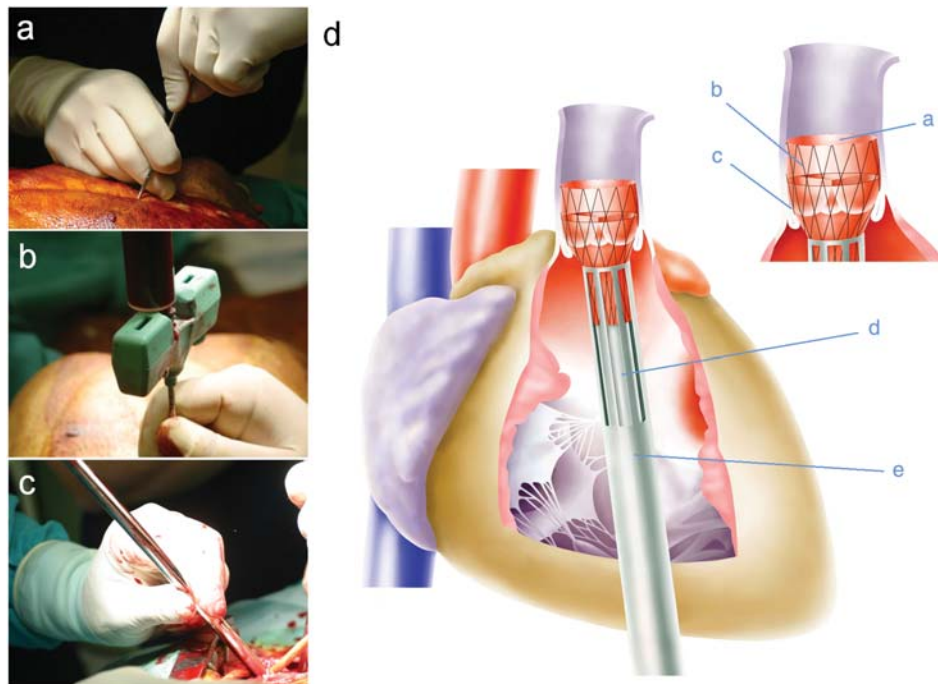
Minimally invasive tissue engineered heart valves implantation. After sternal bone marrow puncture (A) and aspiration of fluid (B), the tissue engineered heart valve was loaded into the delivery device (C), inserted into the right ventricle (D) and deployed in the pulmonary position under sonographic and fluoroscopic guidance. The crimped tissue engineered heart valve (a), integrated into the nitinol stent (b), is carefully deployed into the pulmonary position (c) by slowly advancing the inner pusher (d) into the sheath system (e).
